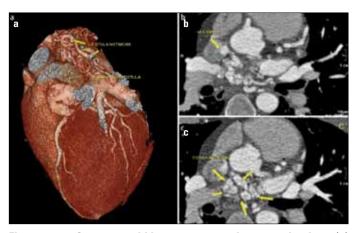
a-c. Coronary multidetector computed tomography views (a) 3-D reconstruction of fistula network (b) fistulae drained into the superior vena cava (c) fistula network
